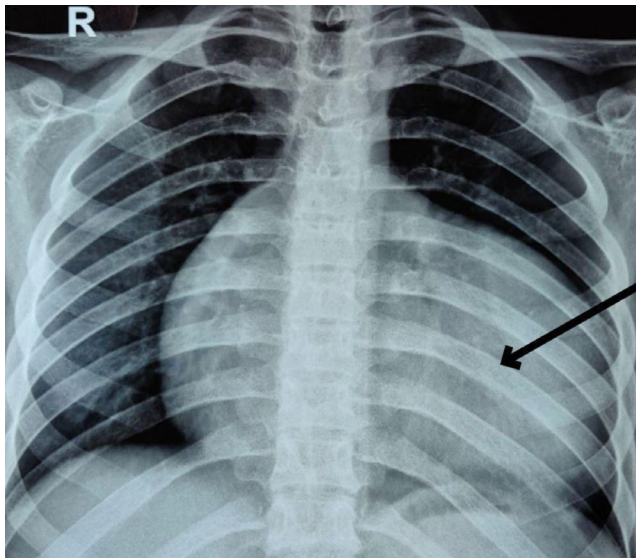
Chest X-ray with posterior–anterior view. Arrow showing cardiomegaly.
